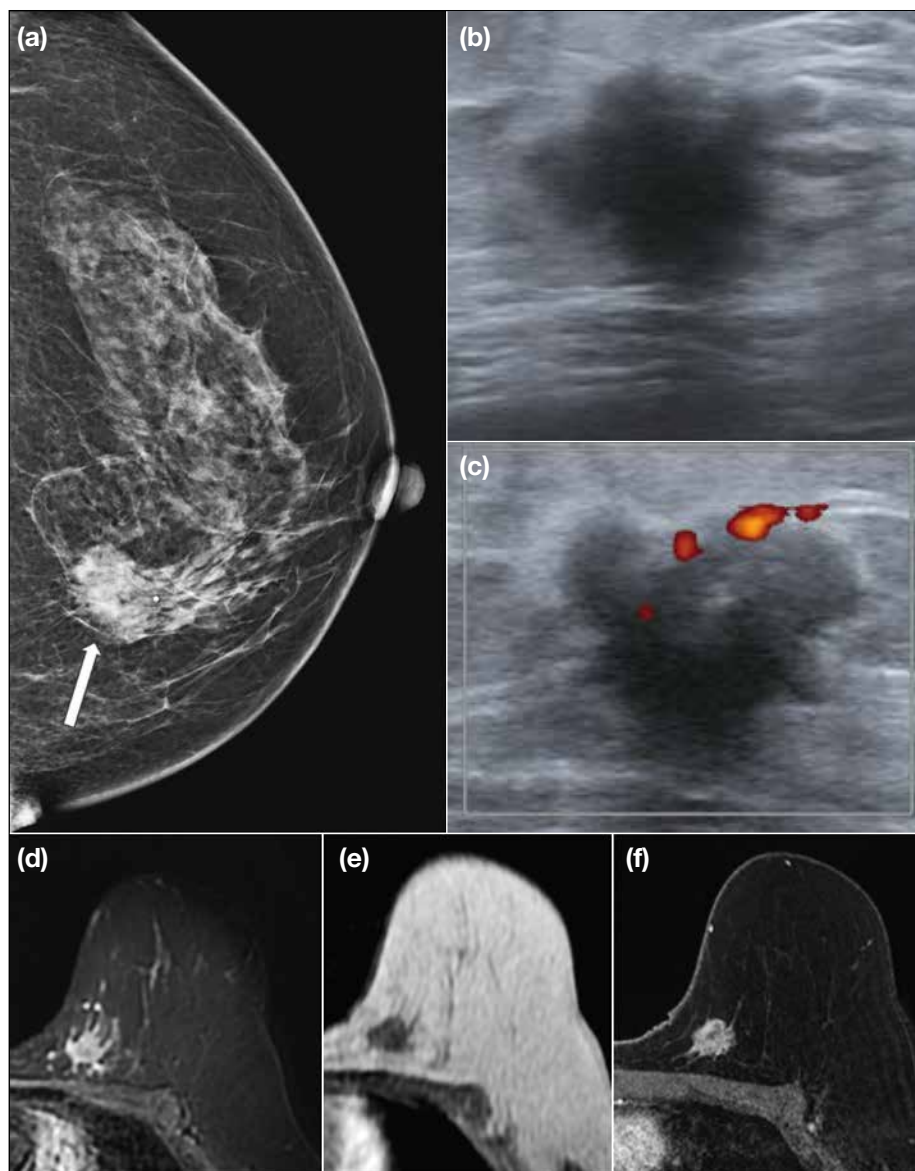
A 59-year-old woman with luminal A breast cancer (oestrogen receptor 95%, progesterone receptor 95%, *c-erbB2* 0+, and Ki-67 ~10%). (a) Craniocaudal mammographic view showing an irregular high-density mass (arrow) with spiculated margins in upper inner left breast. (b) Greyscale and (c) colour Doppler images showing an irregular mass with spiculated margins and intrinsic vascularity. (d) Axial fat-suppressed T2-weighted magnetic resonance (MR) image showing an irregular hyperintense mass with spiculated margins. (e) Axial non-contrast T1-weighted and (f) contrast-enhanced T1-weighted fat-saturated MR images showing heterogenous enhancement in the corresponding mass.
